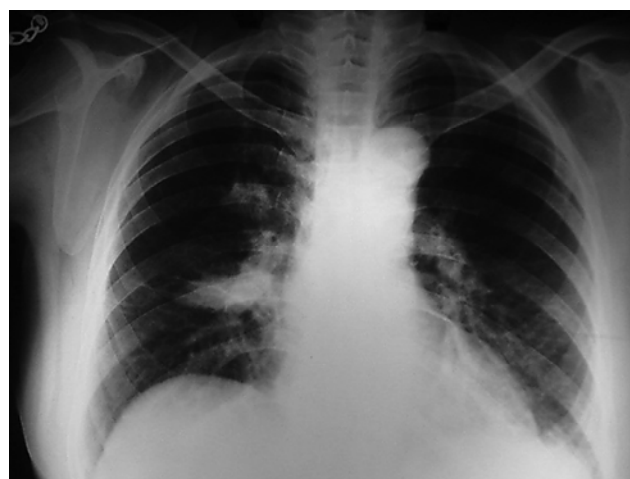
Chest X-ray (posterior anterior view) in a subject suffering from anthracofibrosis. Please note the non-specific infiltration in the left lower zone and the mass lesion in the right lower zone.
